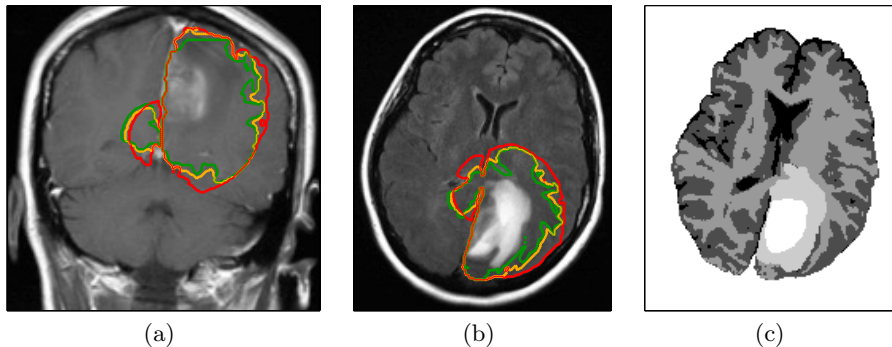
Radiographic appearance of a glioblastoma: (a) coronal T1 weighted post contrast image, (b) axial FLAIR image. The three contours show the model derived target volumes discussed in section 4 (red, $D_w/D_g = 1$; yellow, $D_w/D_g = 10$; green, $D_w/D_g = 100$). Figure (c) shows the brain segmentation into CSF, gray matter, white matter, edema, and enhancing core (from black to white).
